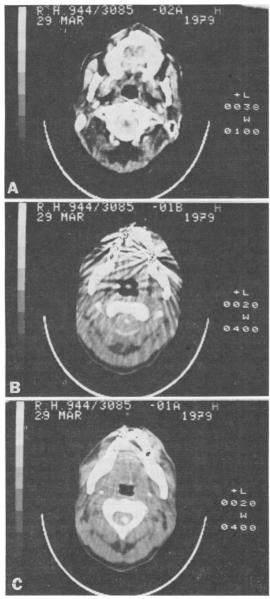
Computed tomogram after myelogram and cndomyelogram. (a) At the level of the upper part of C1 the cord is small and the syrinx is absent. (b) and (c) At lower border of C1 and (c) at C2 the syrinx is present and expands the cord.
